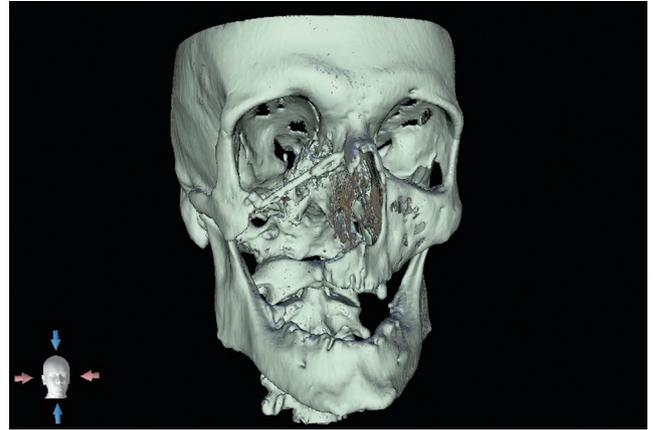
Postoperative computed tomography scan. Three-dimensional view.
